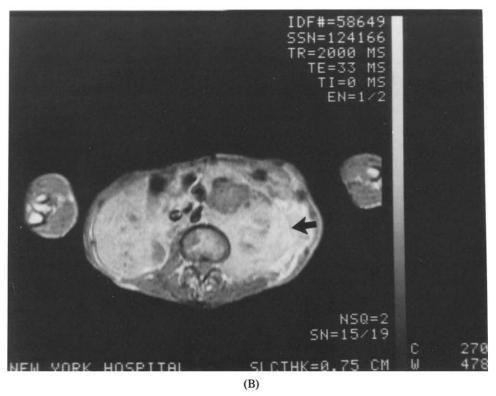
Axial CT and MR (.6 T) images demonstrating large left sided heterogeneous retroperitoneal mass. (A) Postcontrast CT reveals the low density mass (arrow) adjacent to the calcified pseudoaneurysm (open arrow) and aortic graft (curved arrow). (B) SE 2000/33 MR image at same level shows the mass (arrow) to be of intermediate signal intensity. (Figure continued on facing page.)
